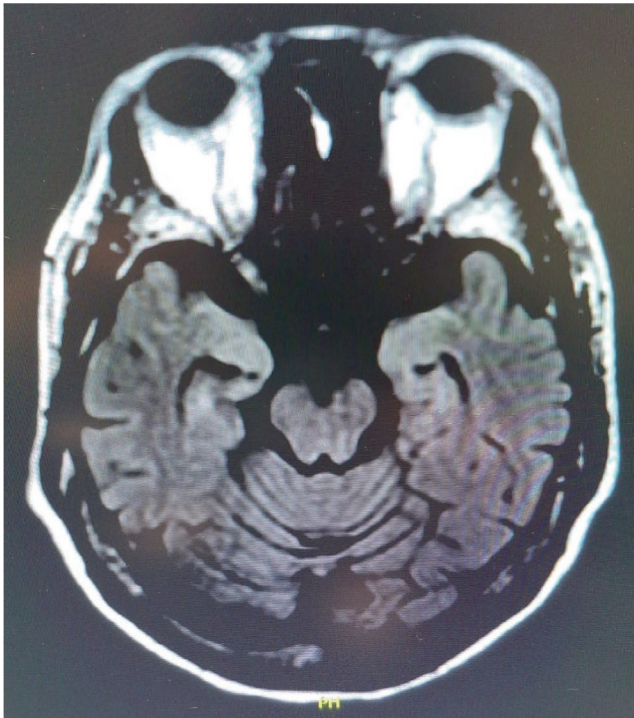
Brain MRI of the second patient showed bilateral hippocampus hyperintensity associated with mild volume loss, compatible with subacute autoimmune encephalitis.
